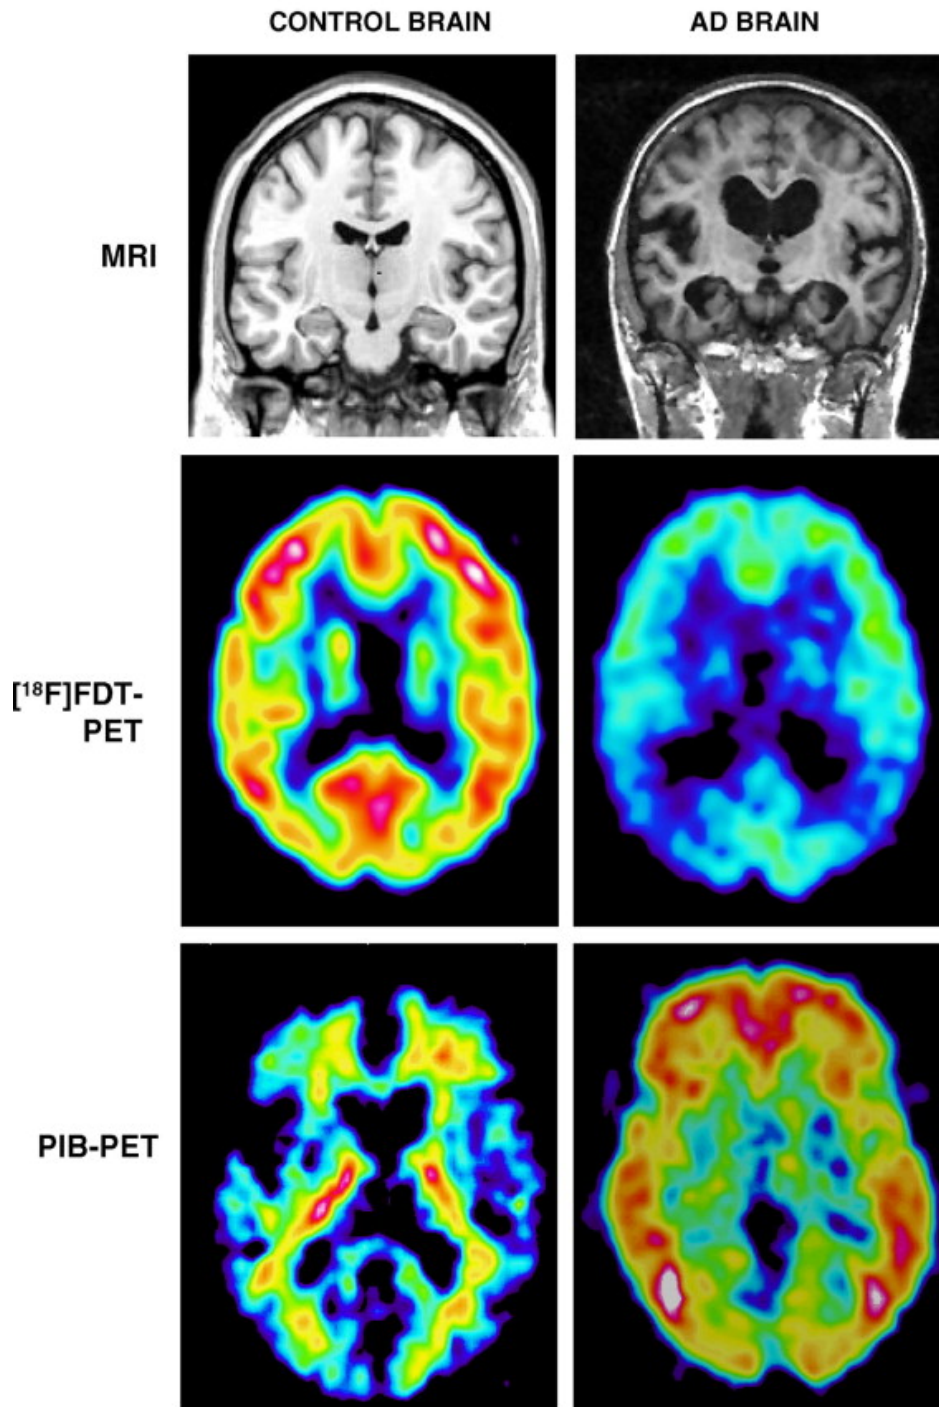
MRI and PET scan of Alzheimer patients and age matched control. MRI scan of AD brain shows symmetric atrophy of hippocampus and enlargement of lateral ventricles. FDG-PET pictures show reduced metabolism (mainly in parital lobes) and PiB-PET shows increased cortical A β burden (Cedazo-Minguez and Winblad (2009))
